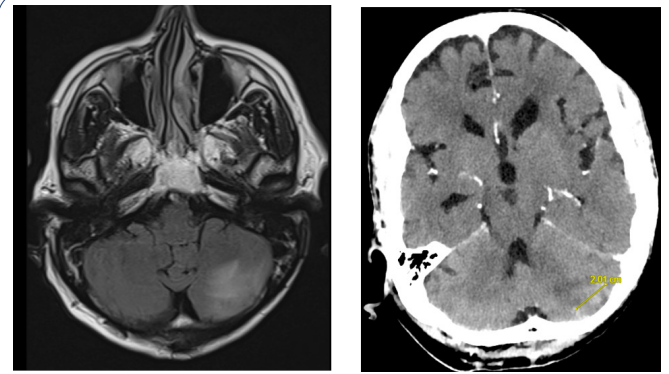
T2 Flair Cerebral Magnetic Resonance Imaging (left) and Injected Cerebral computed Tomography (right) showing the radiological signs of cerebral radionecrosis in the left cerebellum area.
